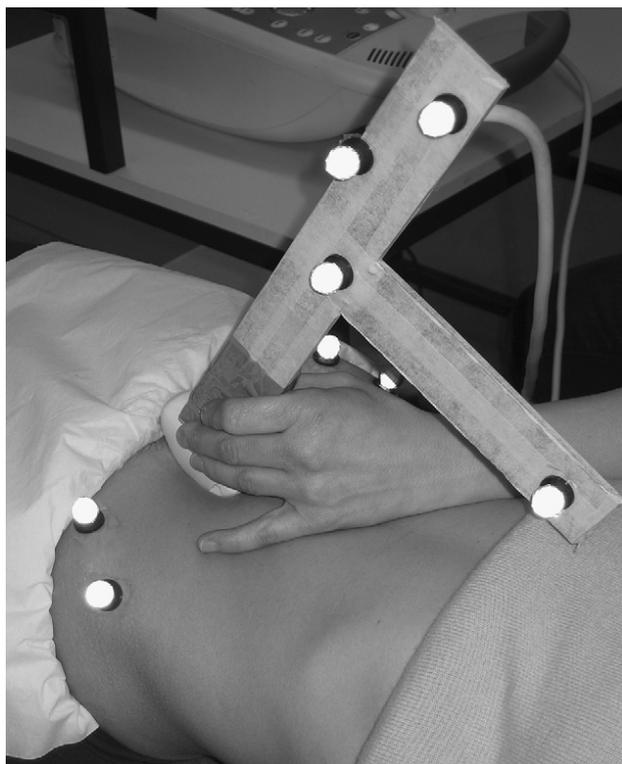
Experimental setup for imaging at the sagittal bladder imaging site. Note the retro-reflective markers on the ASISs, iliac tubercles and wand attached to the ultrasound transducer.
